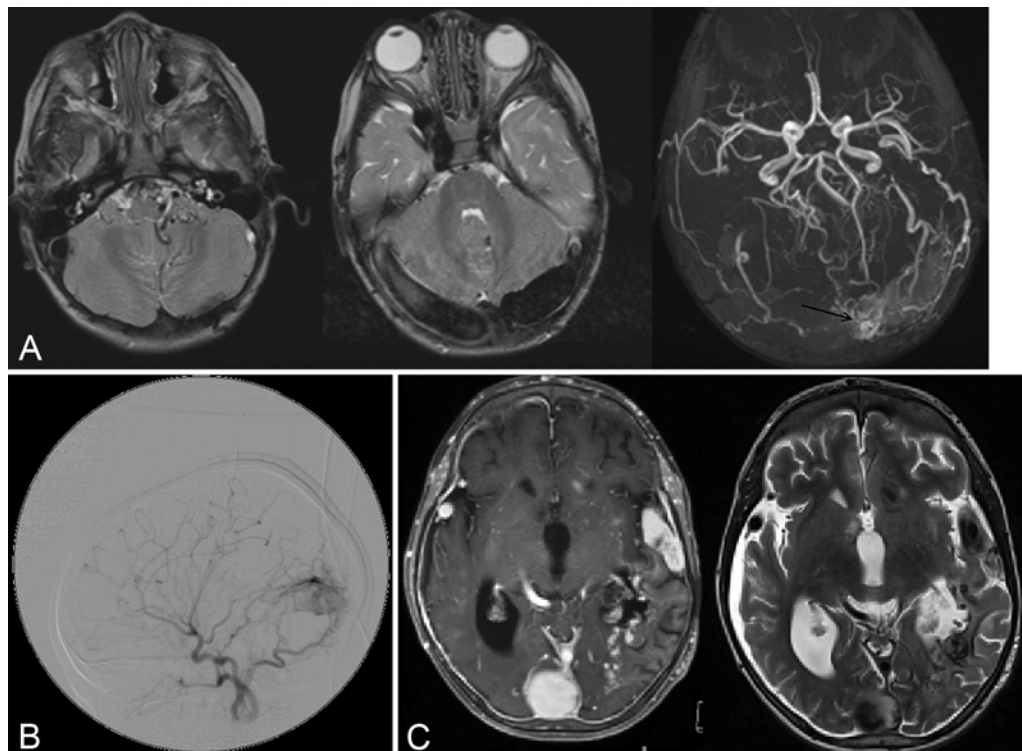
Case 2. A: Axial T2-weighted MR images show occlusive thrombus of the left sigmoid sinus (left) and early thrombosis of the right sigmoid sinus (center). An MR angiogram (right) shows a dAVM (arrow) adjacent to the left transverse sinus. B: Left common carotid angiogram showing a dAVM arising from branches of the left ECA and ICA. C: Axial T1-weighted postcontrast MR image (left) and T2-weighted MR image (right) show left temporoparietal chronic venous ischemic changes, enlarged cortical veins, and dilated torcular herophili.
